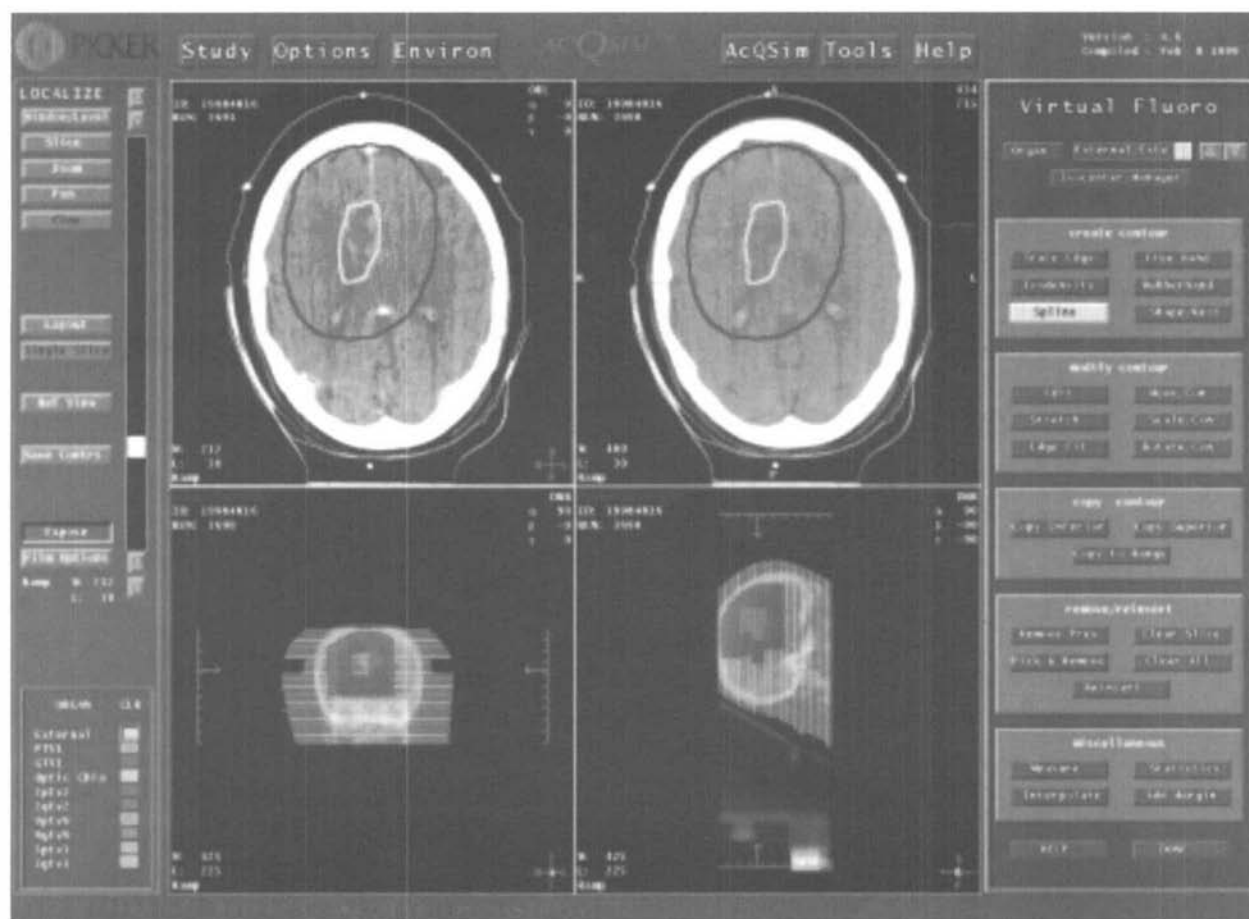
The image fusion workspace showing marked-up contours. If the CT co-ordinates are the same for both scans, enhanced CT data on the left can be automatically fused to the unenhanced data on the right. Contours marked-up on the enhanced scan are then automatically transferred to the unenhanced scan for storage with previous contours. Contours shown are $\text{PTV}_{\text{unenh}}$ (dark line) and $\text{GTV}_{\text{unenh}}$ (light line).
